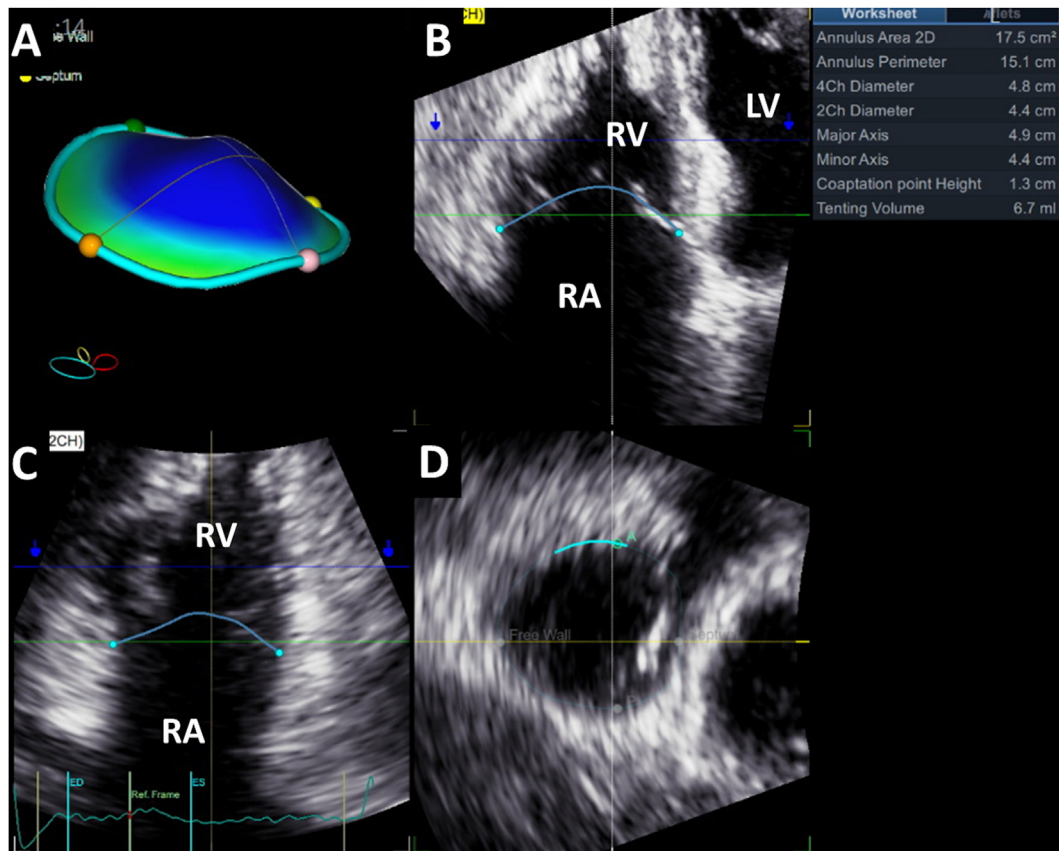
Quantitative analysis of tricuspid annular geometry using a dedicated software package on a transthoracic 3D data set. (A) Surface rendering of the TV in a patient with STR that allows appreciation of its complex 3D shape. The colored dots are used for spatial orientation (yellow, septum; orange, RV free wall; pink, posterior; green, anterior). Indexing of the TV model is done using different cut planes (B, four-chamber view; C, 90° cut plane shown by the white vertical line in the four-chamber view; D, transverse cut plane whose position is shown by the blue horizontal line). 2Ch, Two-chamber; 4Ch, four-chamber; LV, left ventricle; RA, right atrium; RV, right ventricle.
